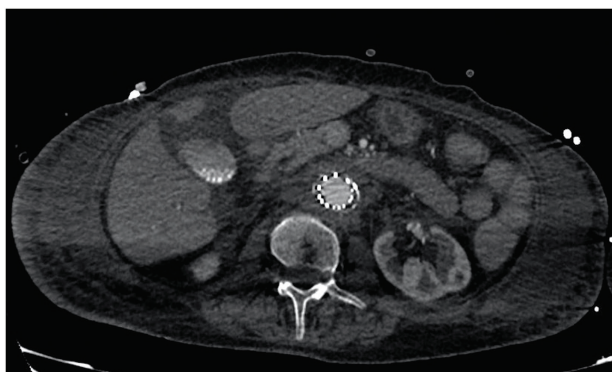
Postoperative follow-up computed tomography angiography (CTA), axial plane: correct cuff position, no active bleeding, endoleaks, or blood in the bowel loops lumen.
